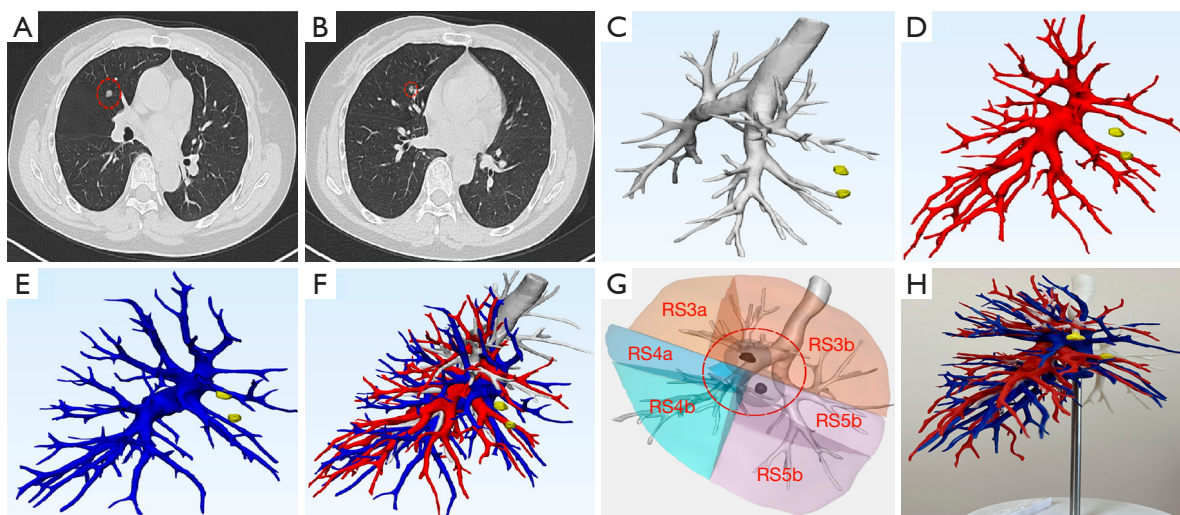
A case of personalized preoperative planning process using 3D-CTBA and 3D printing model. (A,B) The patient's CT showing two mGGN in right lung; red dotted circles indicate the location of the lung nodules. (C-F) The patient's 3D-CTBA reconstruction, including lung bronchus, arteries and veins. (G) The location of the two nodules and the target segments of the lung to be resected; red dotted circles indicate the location of the lung nodules. (H) The patient's 3D printing model provides visualization of the location of the lesion and the anatomy of the target area. 3D-CTBA, three-dimensional computed tomography bronchography and angiography; CT, computed tomography; mGGN, mixed ground-glass nodule.
